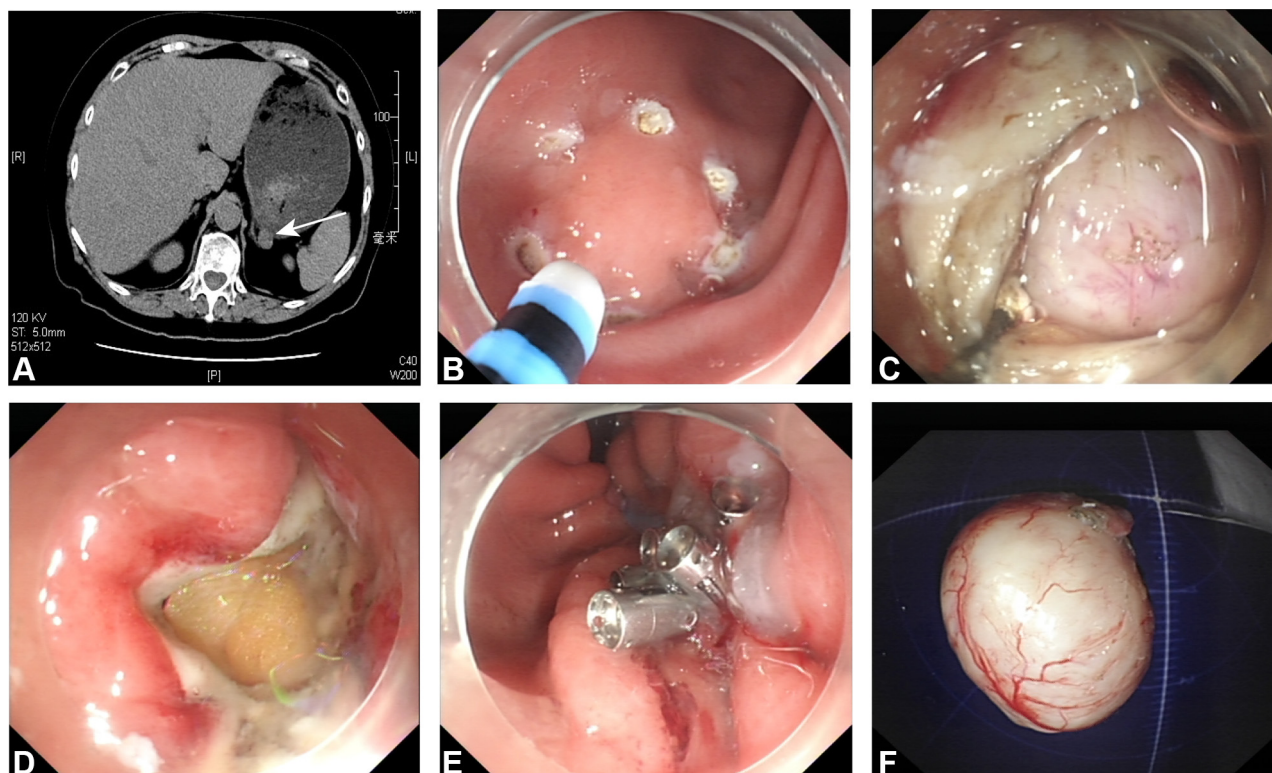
Endoscopic full-thickness resection of a gastric extraluminal tumor. A, CT showing the location of the extraluminal tumor at the fundus of the stomach (arrow). B, Prior incision of the mucosal and submucosal layers surrounding the lesion. C, Tumor exposure after full-thickness myotomy. D, Endoscopic view after tumor removal. E, Closure of the mucosal entry using nylon rope and clips. F, Resected tumor.
